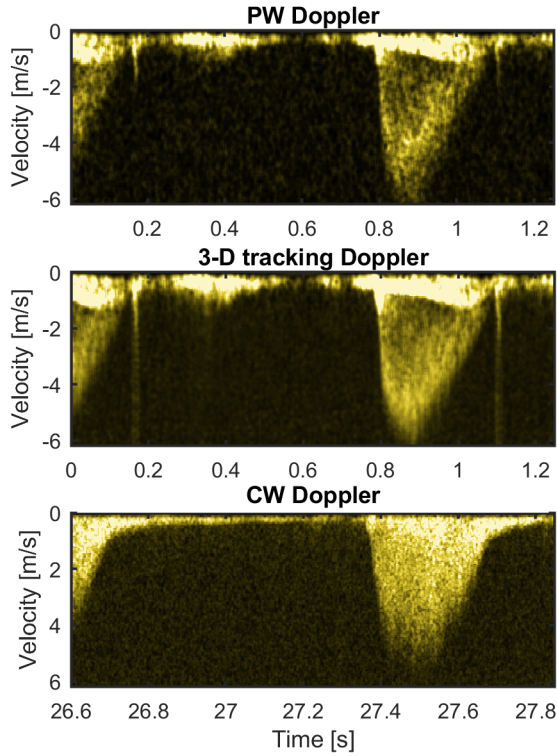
In vivo* example of velocity spectra from subject 2, whose results are summarised in Table III. The estimated beam-to-flow angle was  $57^\circ$ . A CW Doppler spectrum from a right parasternal view is shown for reference.
